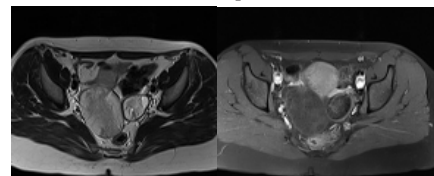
MRI pelvic organs showing adnexal mass with fat component.
